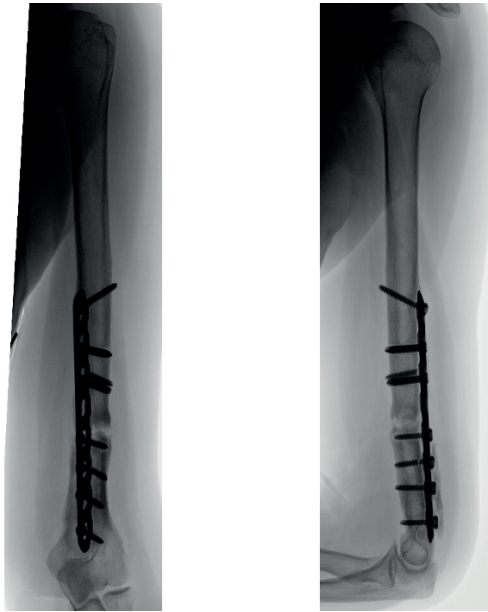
Radiographic images of a representative atrophic humerus nonunion in a 63 year old female after plate-screw osteosynthesis.
